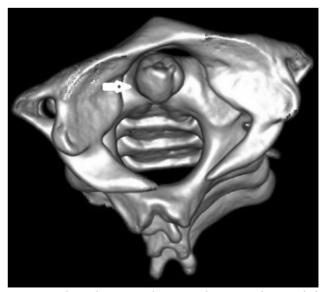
Three-dimensional computed tomography revealed a rotatory atlantoaxial subluxation.
